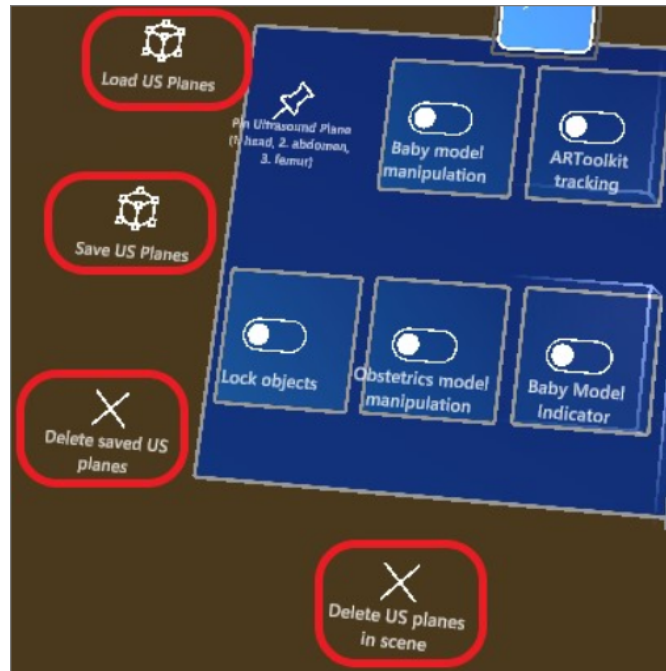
A close-up of the user menu. These functions allow the trainer to save the relative locations of the marked ultrasound planes and to reload them, as desired. It is also possible to delete the planes, if this is desired.
